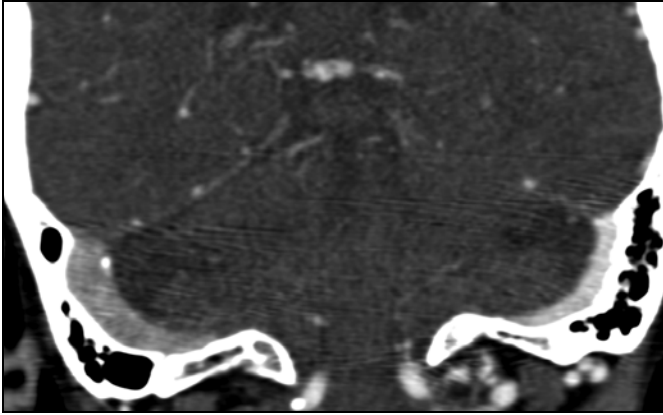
77-year-old woman with type 2b dural arteriovenous fistula at junction of left transverse and sigmoid sinuses. Reconstructed coronal CT angiographic image of posterior fossa obtained at level of foramen magnum shows filling of left transverse sinus with high-contrast arterialized blood. Right transverse sinus shows less intense venous contrast filling.
